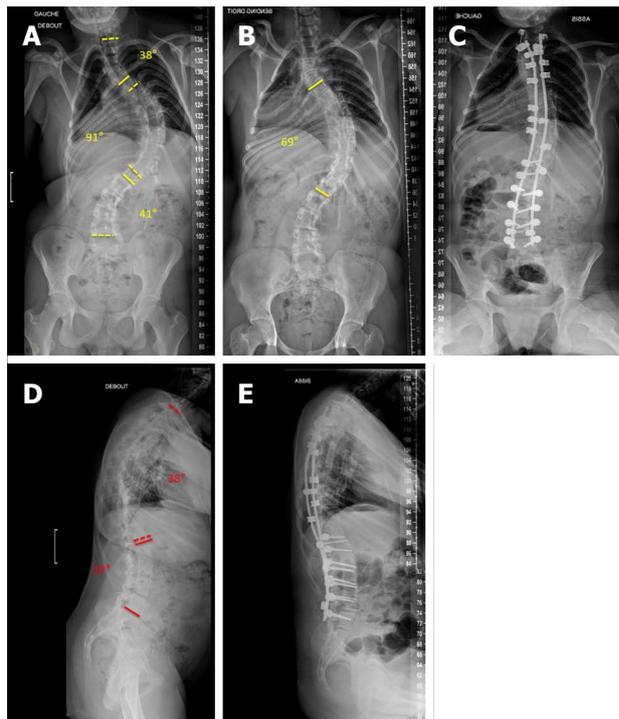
A 15-year-old boy with a genetic syndrome. This ambulatory patient was operated on with a hybrid construct. A: Pre-operative standing anteroposterior x-rays; B: Pre-operative supine left bending X-rays (reducibility of 24%); C: Post-operative seated anteroposterior X-rays; D: Pre-operative standing lateral X-rays; E: Post-operative seated lateral X-rays.
